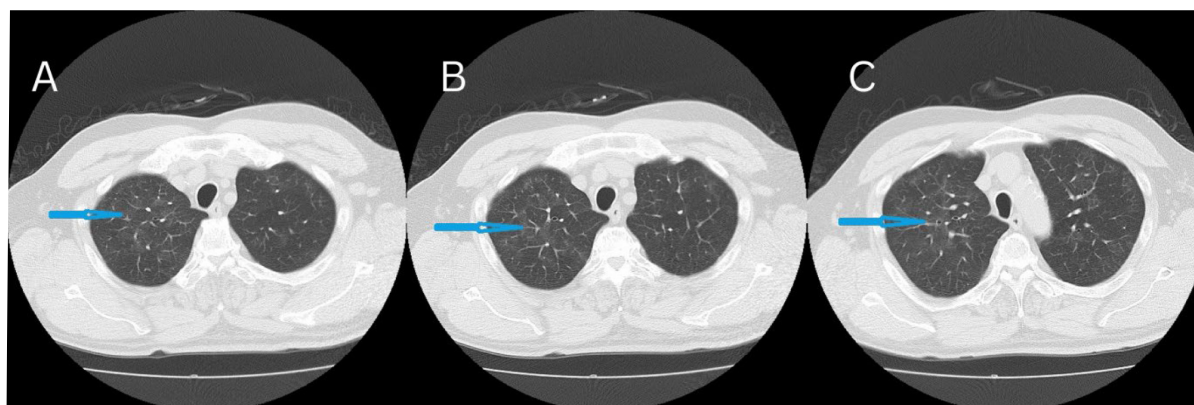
Chest computed tomography (CT) post-hospital discharge.
